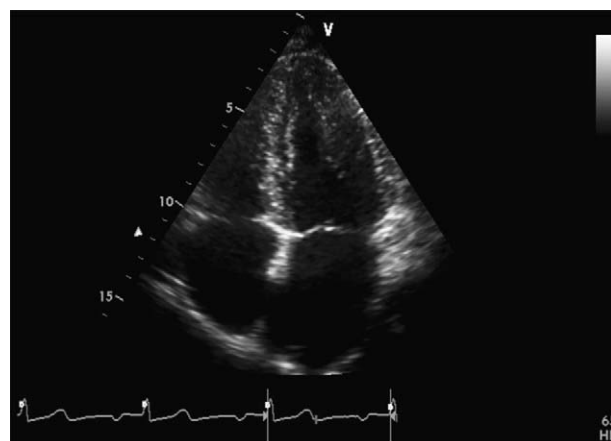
Transthoracic apical 4-chamber view showing marked thickening of the basal interatrial septum and basal lateral atrial wall.
